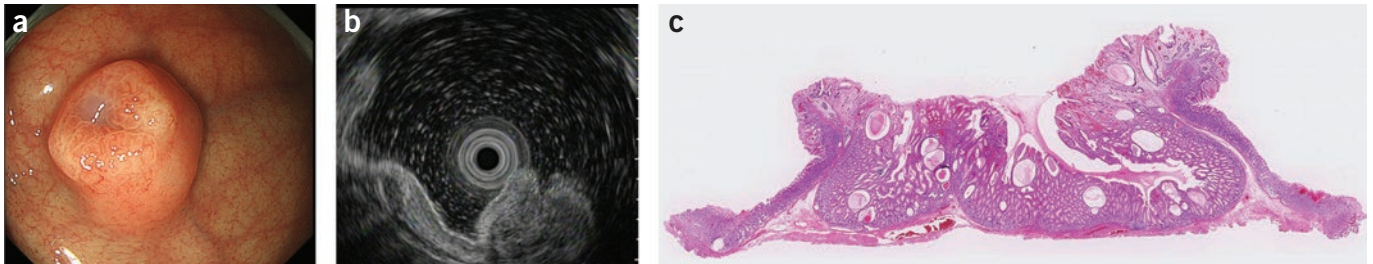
A 37-year-old woman was admitted to our hospital with a gastric submucosal tumor that had been detected in gastrointestinal endoscopy screening. The lesion, 10 mm in diameter, was located at the fornix of the stomach. Milky mucus flowed from a small orifice at the top of the lesion, making it look like a papilla (a). Endoscopic ultrasound revealed a heterogeneous lesion containing small cystic areas, located in the third layer of the gastric wall (b). Endoscopic submucosal dissection (ESD) was performed to remove the lesion en bloc. Pathologically, the lesion was covered with invertedly proliferating columnar epithelium and was composed primarily of hyperplastic foveolar-type glands with focal dilatation of the cystic duct (c). Therefore, the final diagnosis was gastric inverted hyperplastic polyp (GIHP) without adenocarcinoma. A GIHP is a rare entity characterized by the downward growth of hyperplastic mucosal components into the submucosal layer. It is usually asymptomatic and found incidentally. Endoscopic ultrasound is useful for the diagnosis of GIHP. Although basically benign, GIHPs tend to harbor foci of adenocarcinoma. Therefore, en bloc resection with ESD is the treatment of choice, enabling adequate pathological assessment. (Informed consent was obtained from the patient to publish these images.)
